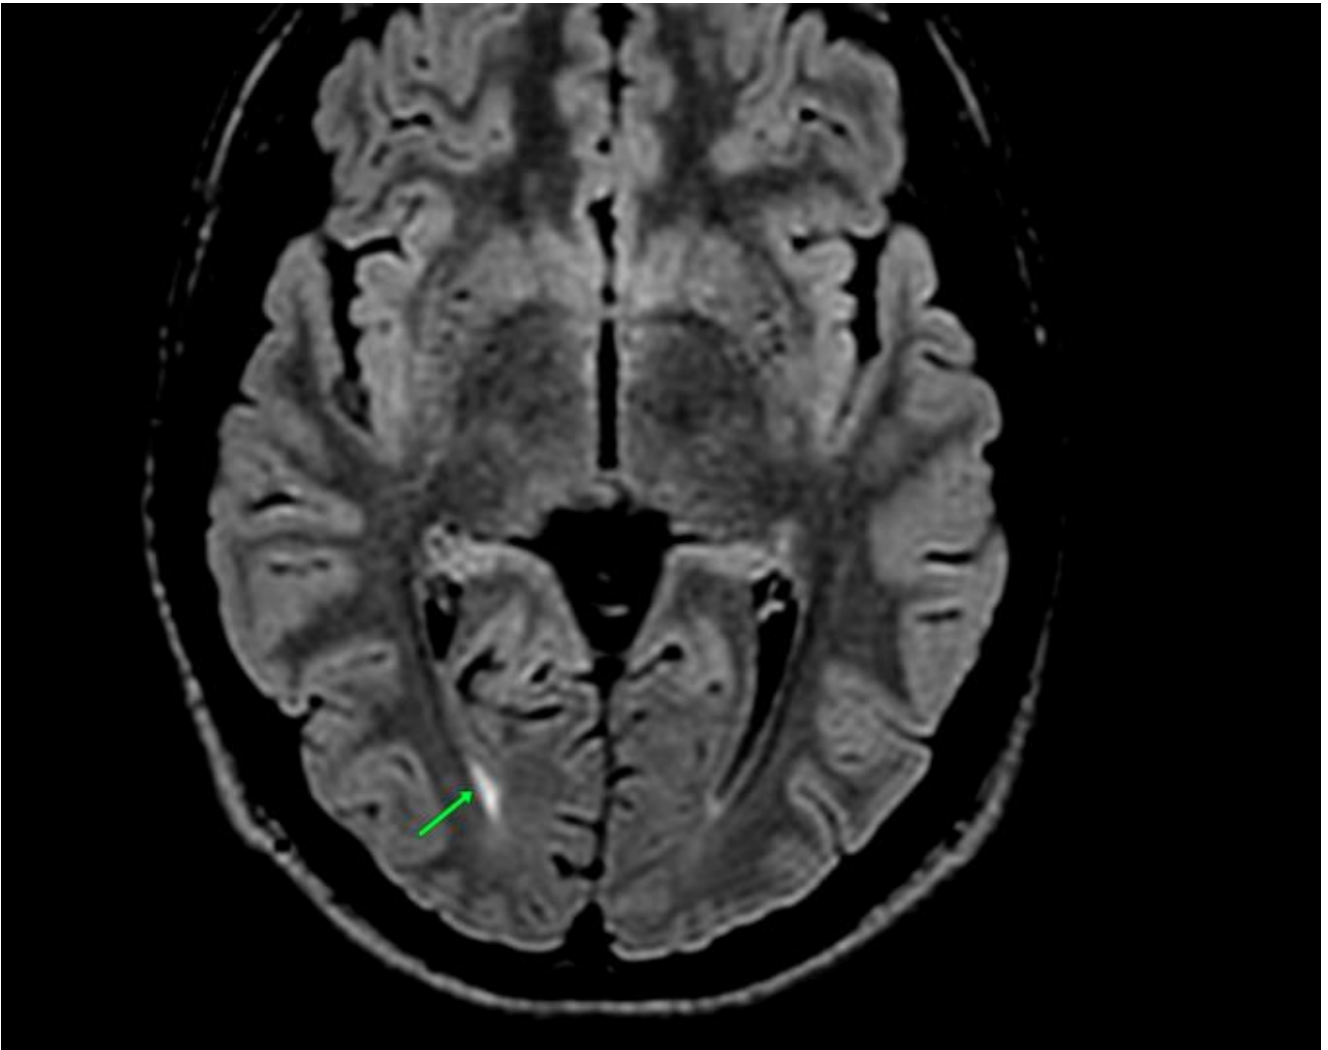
It is not unusual to see periventricular and ependymal swelling (T2 FLAIR hyperintensities) in cases where the intraventricular pressure is elevated.
